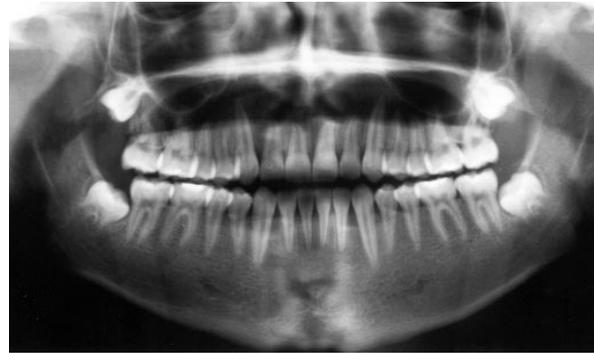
Posttreatment panoramic x-ray film.
